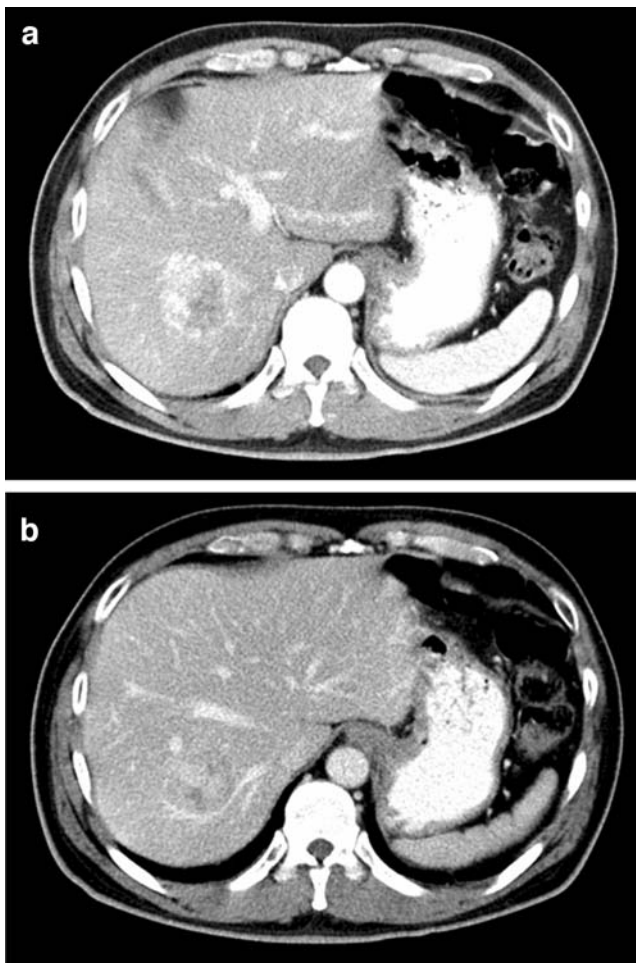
Computed tomographic findings of a primary neuroendocrine tumor of the liver (case 4). a At the arterial phase, a 5 cm-sized hypervascular mass was identified with a background of chronic liver disease. b Tumor hypervascularity was attenuated at the portal phase. These findings are compatible to those of usual hepatocellular carcinoma.
